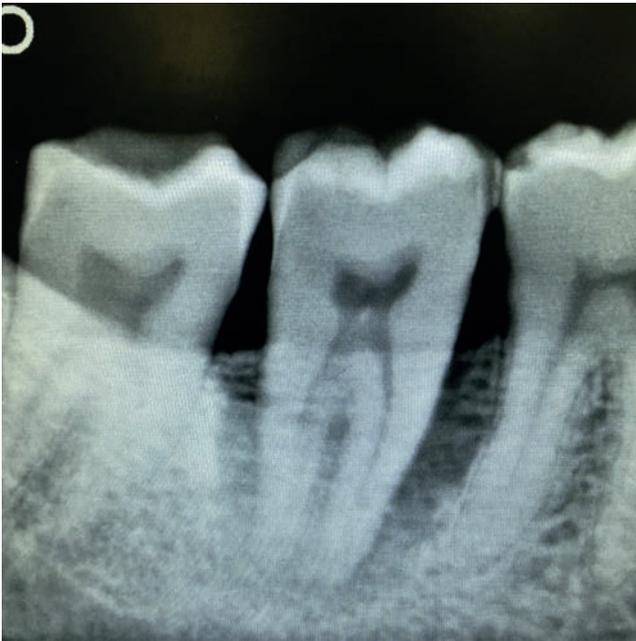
Intra oral periapical radiograph shows horizontal bone loss. It is noticeable that there is no radiographic sign for VRF, but the horizontal bone loss can be an indication for that.
